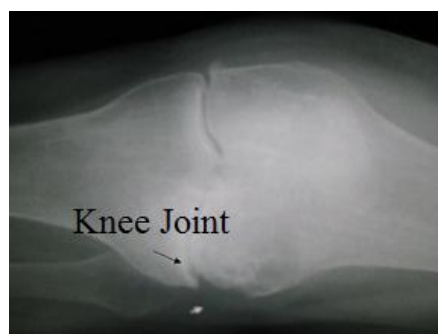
X-ray image of right knee
